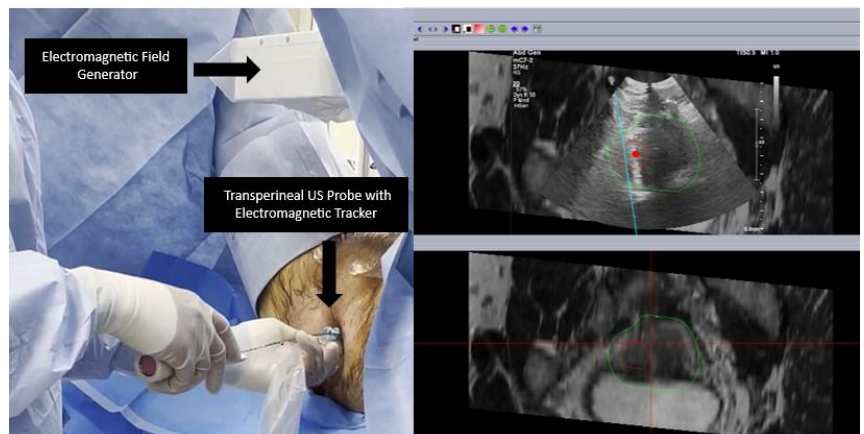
Totally Transperineal (TTP) MRI/US fusion biopsy technique (Left) and Software interface demonstrating transperineal ultrasound fusion to MRI (Right)
